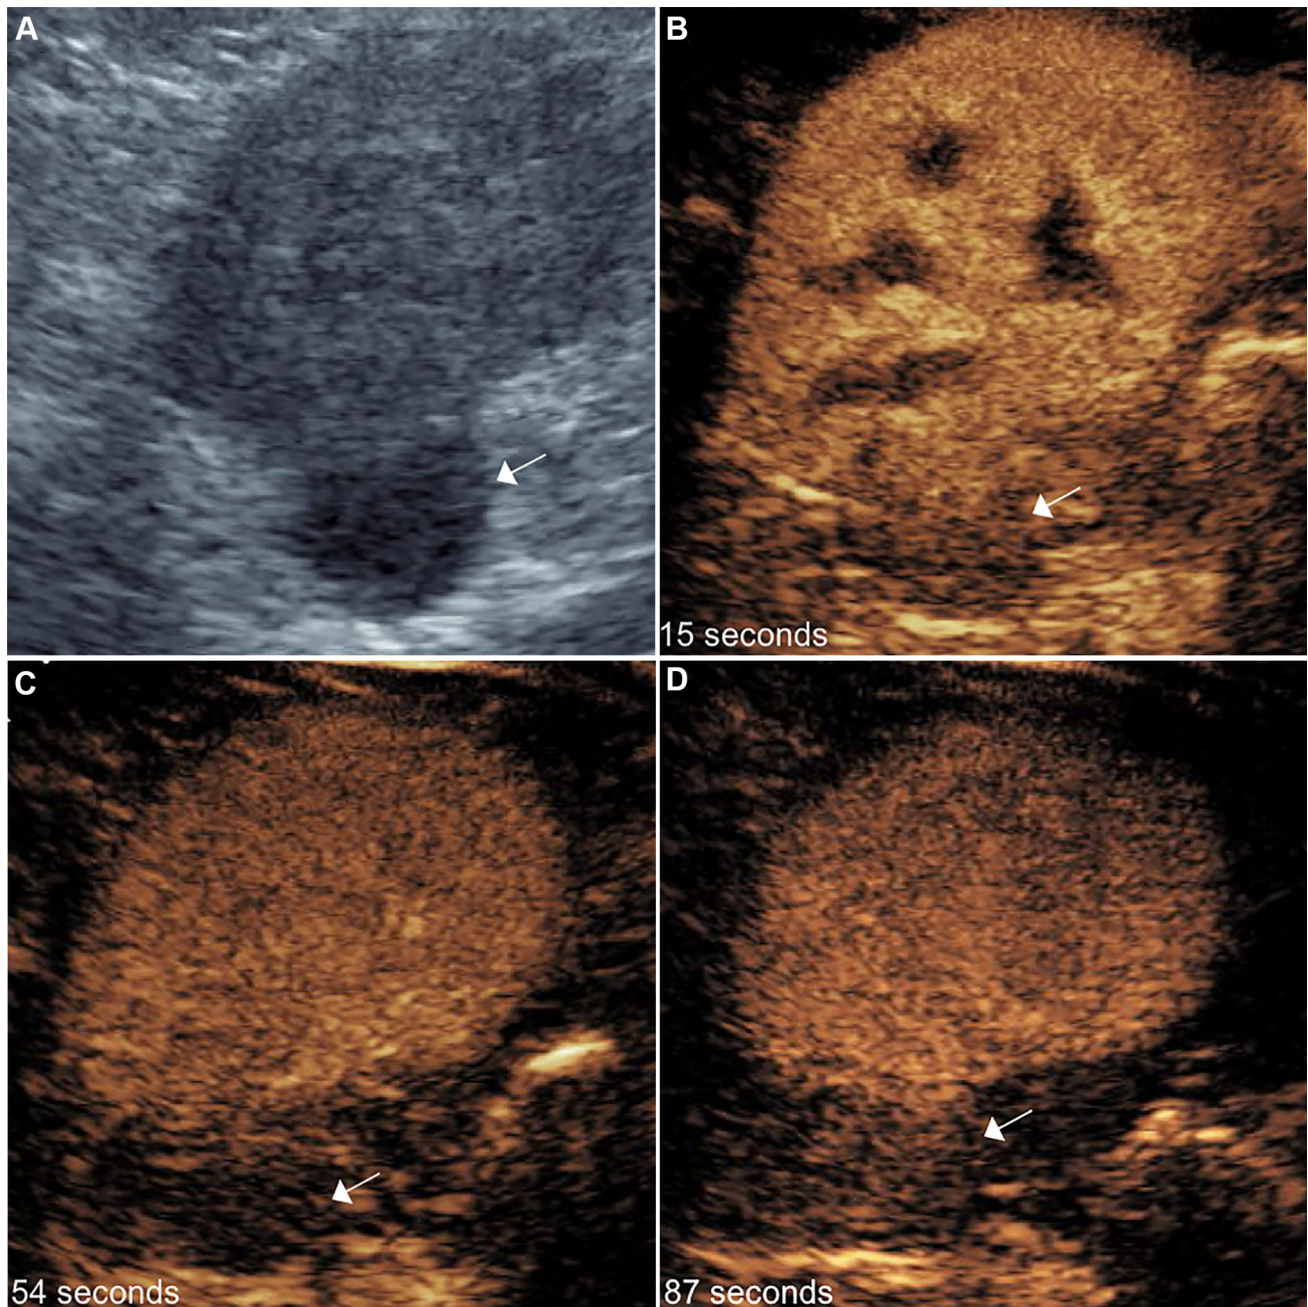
A 45-year-old male with right renal mass detected on CT urogram. A Grayscale ultrasound image of the right kidney demonstrates a round, hypoechoic, exophytic mass at the upper pole (*arrow*). B CEUS obtained in the arterial phase (15 s) demonstrates mild enhancement of this mass to a
